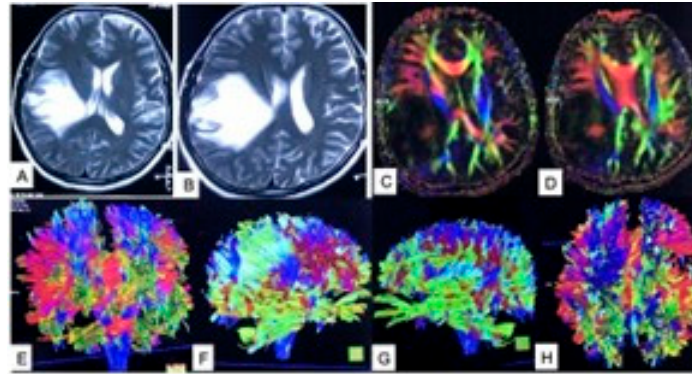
(A,B) MRI of brain T2W images showing right fronto-parieto-ganglionic glioma. (C,D) MR diffuse tensor imaging (DTI) of same patient in axial views showing displacement of adjacent white fiber tracts. (E–H) Tractography of the same patient in different views. Source: Figure by authors.
